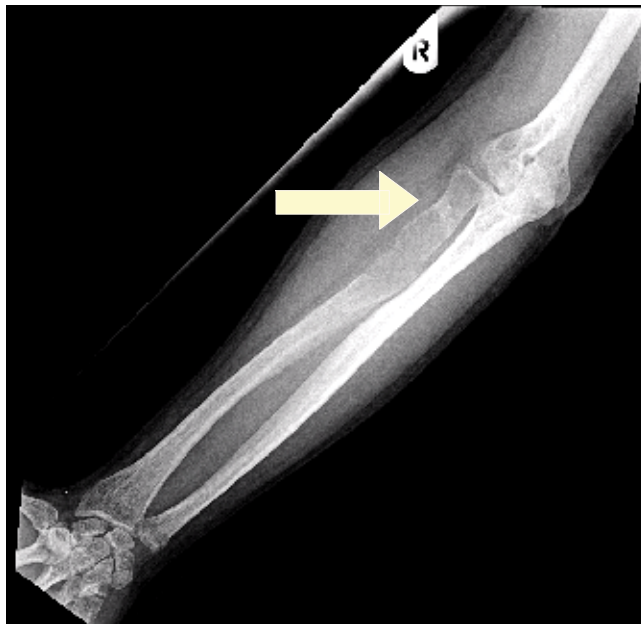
Radiograph of the right radius and ulna shows a lytic lesion at the proximal radius with a healing pathological fracture. (Arrow)
